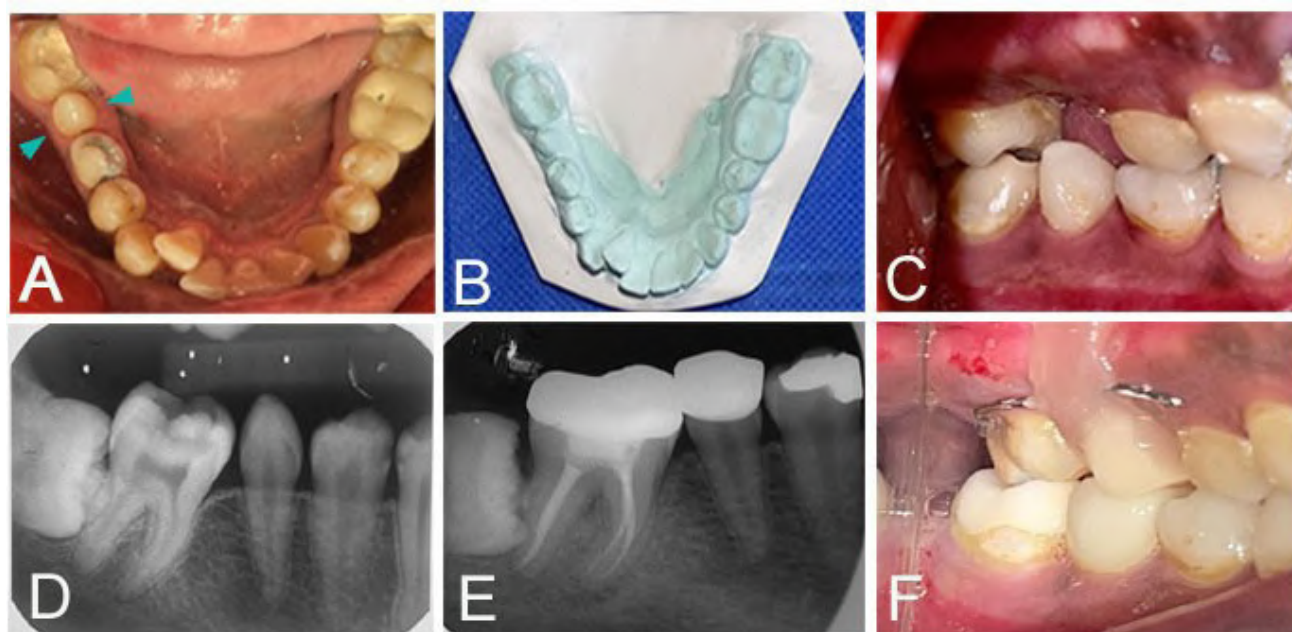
A: Intra-oral view of #47 with adjacent missing first molar (#46) and presence of supernumerary Parapremolar (Green arrow heads). B: Cast model of the mandibular arch. C: Buccal view of the supernumerary tooth. D: Pre-operative Intraoral periapical radiograph. E: Post-operative Intraoral periapical radiograph. F: Postoperative buccal view after post-endodontic restoration.
